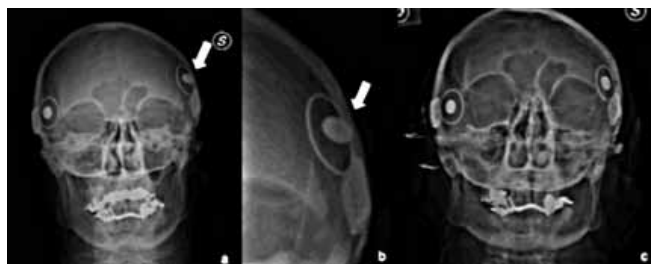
Anteroposterior skull radiograph. (A) Left magnet (white arrow) migration is evident. (B) Detail of left displaced magnet. (C) Normalized position of magnet after revision surgery.
